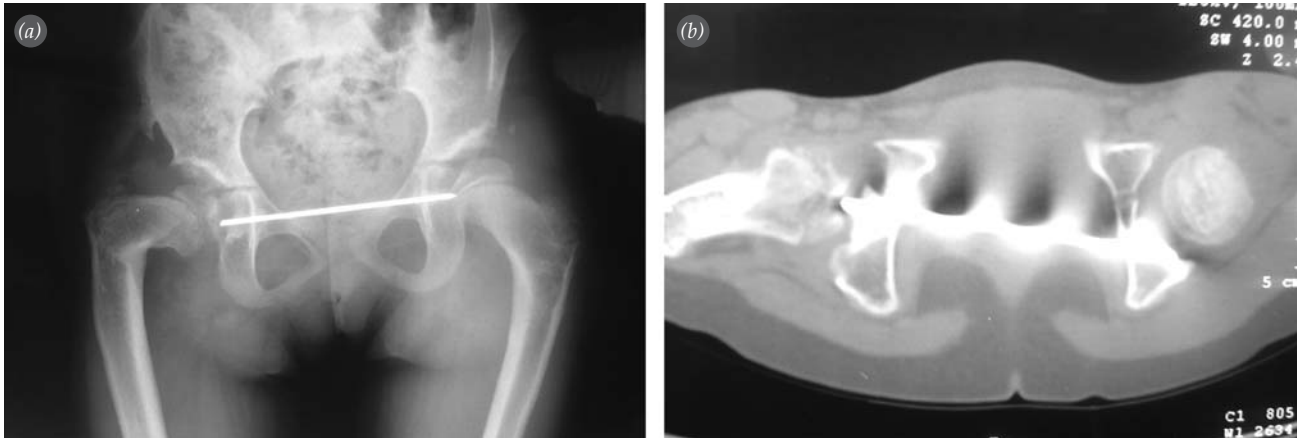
The appearance of K-wire which stands between bilateral hemipelvis like a bridge, cartilaginous lesion in medial side of right caput femoris, and varus deformity in proximal side of right femur in the (a) radiograph and (b) computed tomography image of the pelvis.
